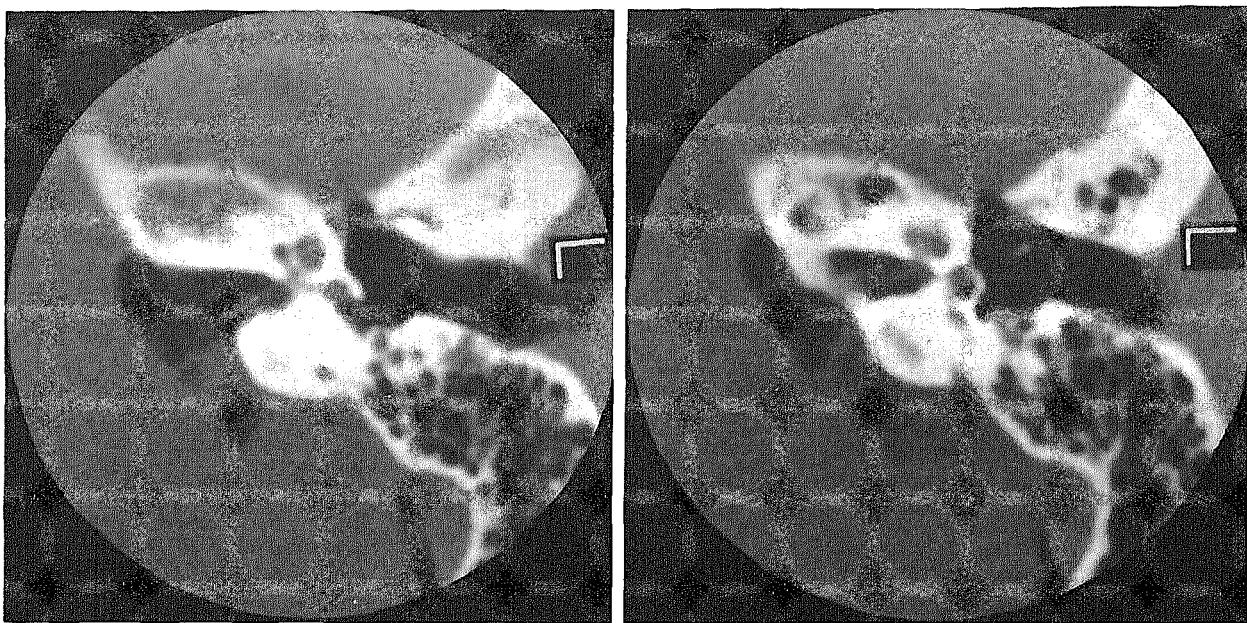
Normal CT pneumocisternogram, axial sections. Gas fills the left cerebellopontine cistern and internal auditory canal. The seventh (anterior) and eighth (posterior) cranial nerves are seen coursing from the brainstem to the fundus of the internal auditory canal.
